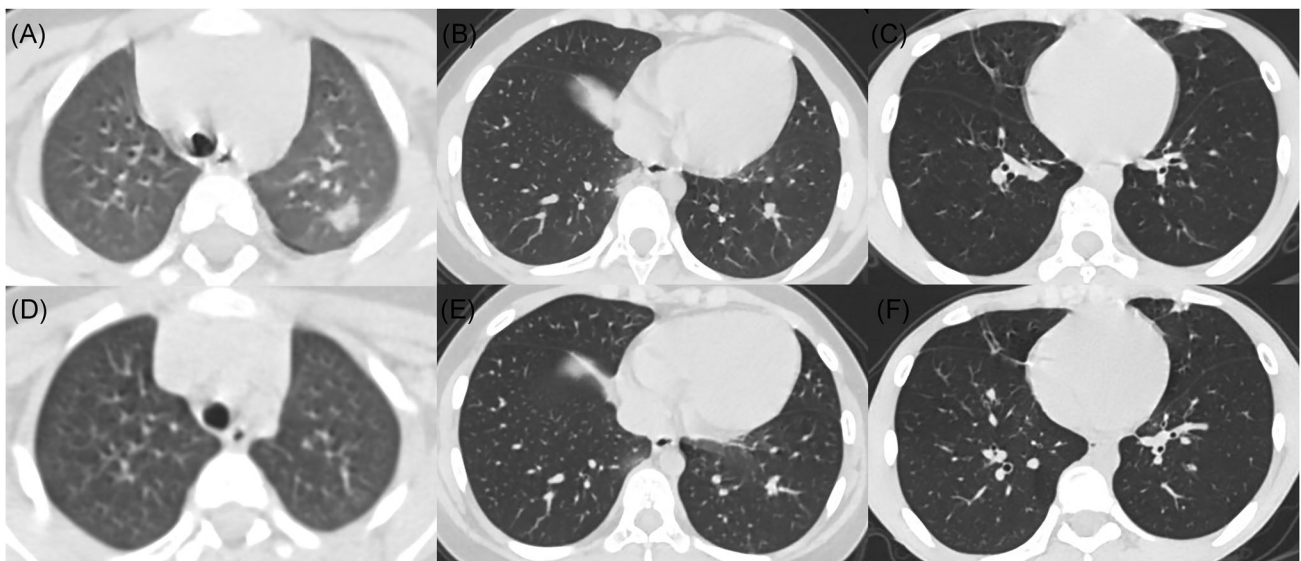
A, Male, 3 years old. On admission, chest CT showed consolidation in the posterior segment of the upper lobe of the left lung with a surrounded halo sign. B, Female, 8 years old. On admission, chest CT showed patchy consolidation with halo sign in the basal segment of the inferior lobe of the right lung, and ground-glass opacities in the inferior lobe of the left lung. C, Male, 14 years old. On admission, chest CT showed consolidation with halo sign in the lingular segment of the left lung, and fibrous cords in both lungs. D, The same patient of (A), 11 days after admission, chest CT showed that the consolidation in the posterior segment of the upper lobe of the left lung was disappeared. E, The same patient of (B), 4 days after admission, chest CT showed shrunken lesions with lower density in the inferior lobes of both lungs. F, The same patient of (C), 3 days after admission, chest CT showed a contraction of consolidation in lingular segment of the left lung, the disappearance of halo sign, and fibrous cords left in both lungs. CT, computed tomography
